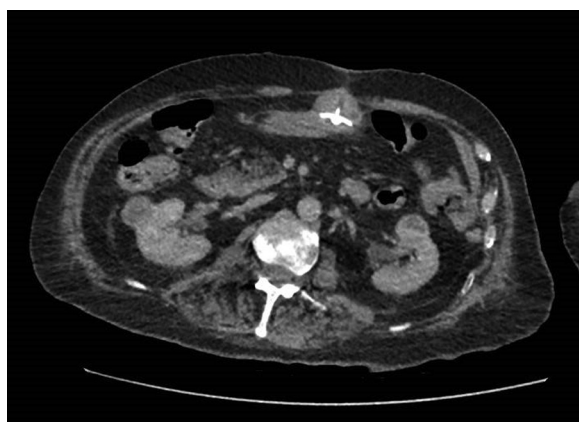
Buried bumper at CT.
